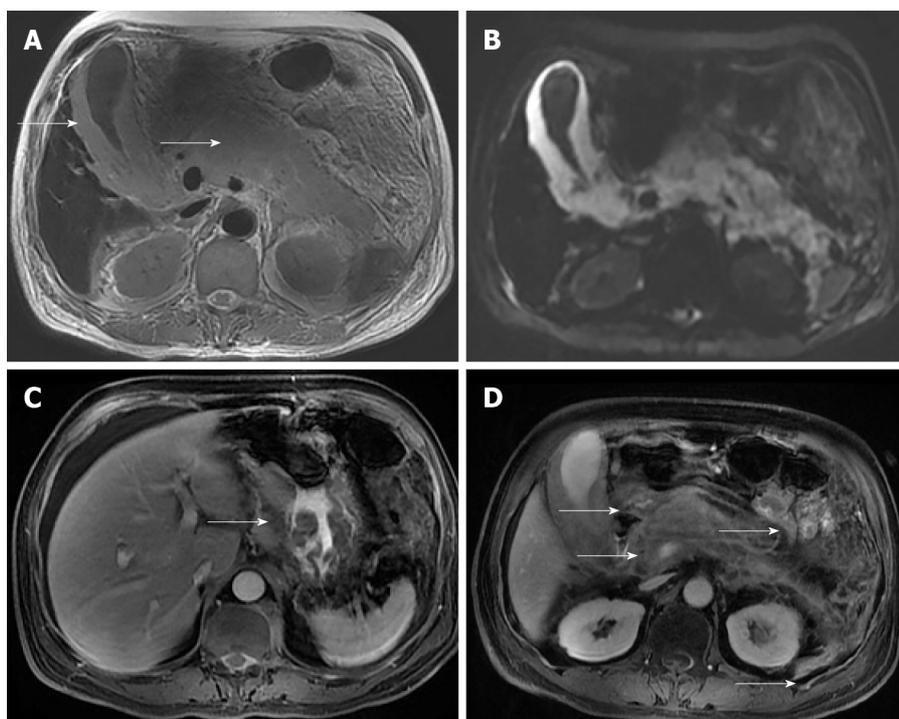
Magnetic resonance imaging of the abdomen at diagnosis. A: Axial T2-weighted magnetic resonance imaging (MRI) demonstrates homogeneous, hyperintense lesion in the whole pancreas and a markedly swollen gallbladder (arrows); B: Diffusion-weighted MRI shows abnormal hyperintensity in gall bladder wall and pancreas; C: Axial contrast-enhanced T1-weighted MRI shows the abnormal thickened lesions of the gastric wall (arrows), which display contrast enhancement in a \times homogeneous fashion; D: Axial contrast-enhanced T1-weighted MRI shows the swollen gallbladder and multiple enlarged retroperitoneal lymph nodes (arrows), which display contrast enhancement in a homogeneous fashion.
